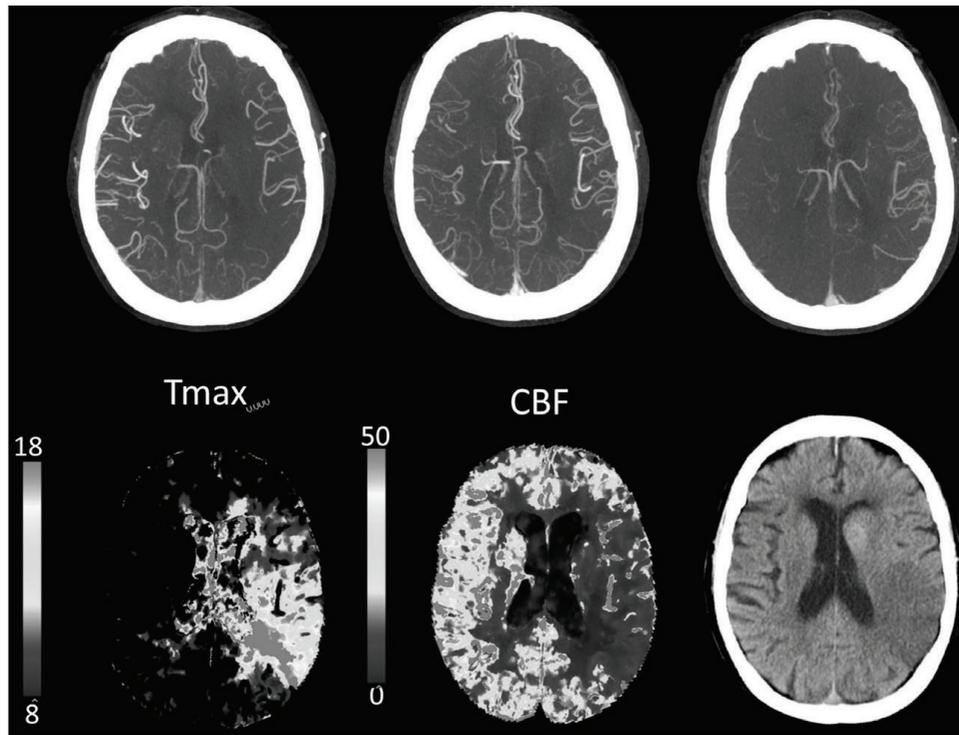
Multiphase computed tomographic angiography (mCTA; 3 phases) maximum intensity projection images and computed tomographic perfusion (CTP) functional maps performed at 2h 57 min post symptom onset for a patient with baseline NIHSS of 13 and left middle cerebral artery M1 segment occlusion. The multiphase CTA scoring within M4-M6 is congruent with the CTP Tmax profile: the M4 region shows no delay and good washout of contrast filling within pial vessels on mCTA with $T_{max} \approx 8-10$ s; the M5 region shows 1-phase delay and poor washout on mCTA with T_{max} of ≈ 16 s; the M6 region shows 2-phase delay and reduced extent with T_{max} of ≈ 20 s. Recanalization occurred 96 min post CTP. Follow-up noncontrast CT shows that M5 and M6 regions went on to infarction. T_{max} =seconds, cerebral blood flow (CBF)= $\text{mL} \cdot \text{min}^{-1} \cdot (100 \text{ g})^{-1}$.
